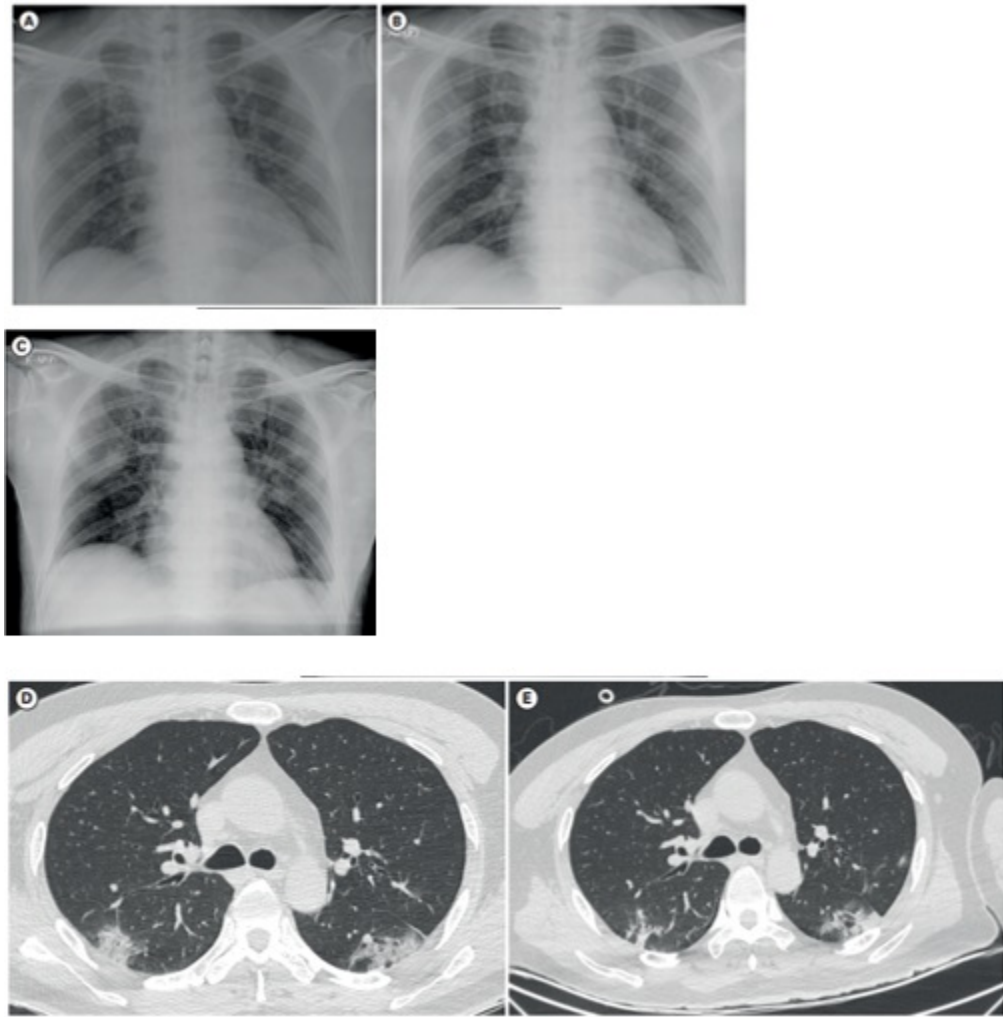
A. Radiography on the 3rd day of the disease. B. 9th day, C. 15th day CXR. D. 9th day tomography. E. 15th day tomography.
